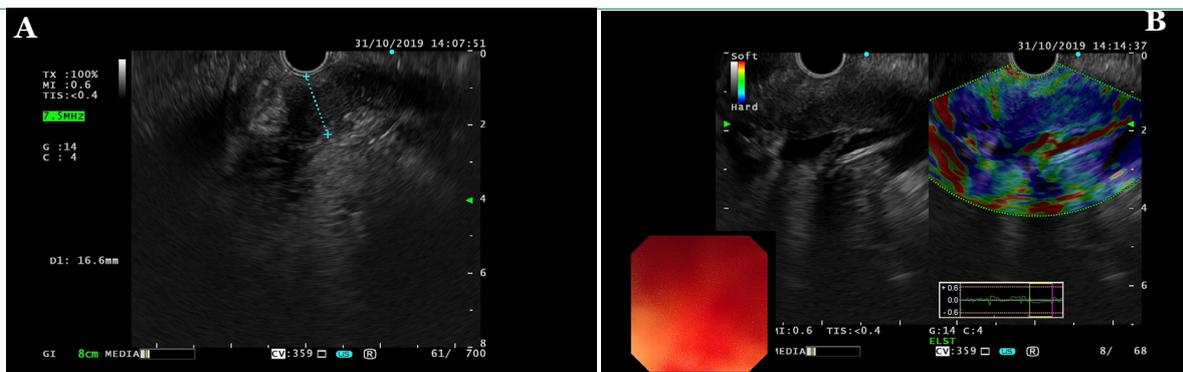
Endoscopic ultrasonography showed the gastric wall hierarchy was disappeared in the gastric antrum and the antrum wall was markedly thickened (A) and Elastography suggested that the lesion was hard (B).
